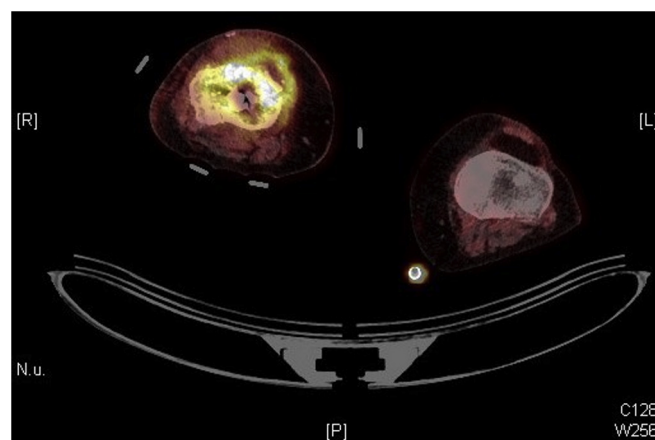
FDG-PET/CT showed increased metabolism in the periprosthetic soft tissues of the right knee.
